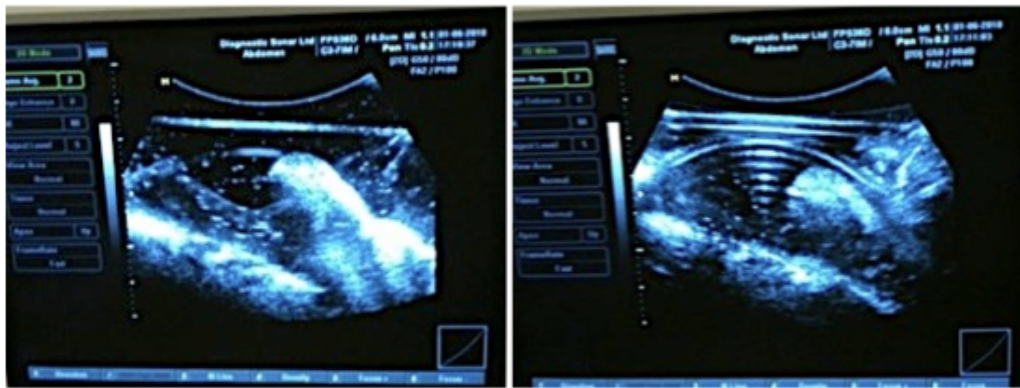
Ultrasound imaging with support plates above the transducer: LDPE (Low Density Polyethylene) (left); P1-M (right).
